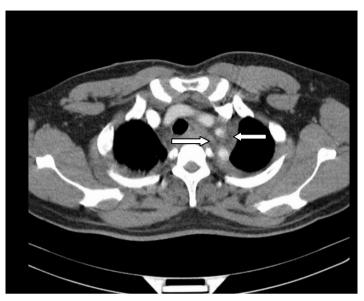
CT with IV contrast at the level of the arch vessels which shows a significant mediastinal hematoma surrounding the aortic arch vessels (white arrows). There is evidence of tracheal shift to the right of the midline by the mediastinal hematoma.
